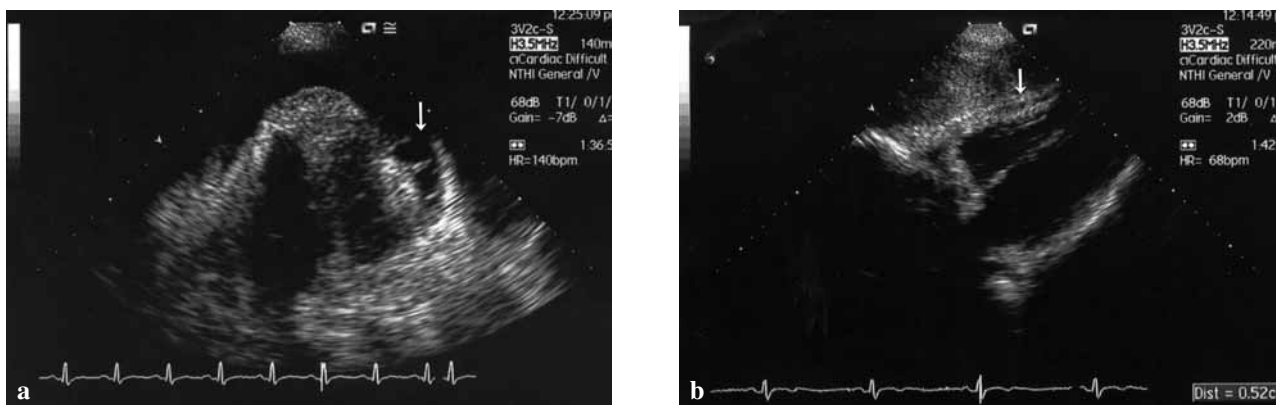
a. Echocardiogram at diagnosis, showing pericardial effusion ; b. Follow-up echocardiogram obtained a week later, showing regression of the effusion.
